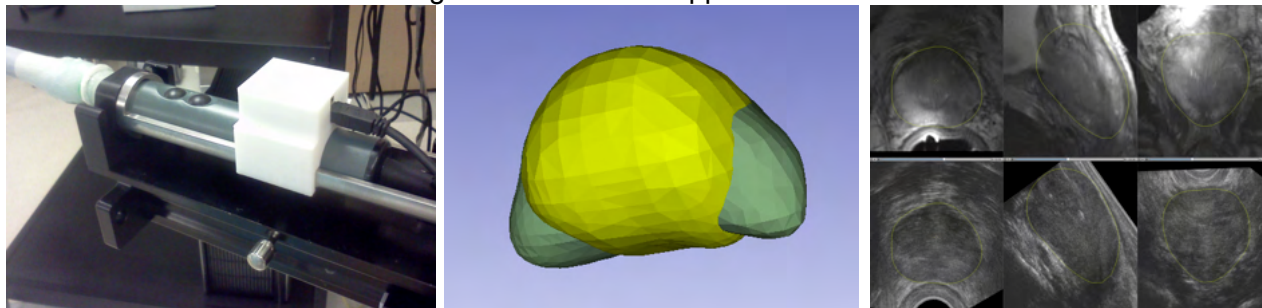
Left: transrectal probe setup with the tracking device attached. Middle: Rendering of the prostate gland surfaces recovered from MRI (green) and reconstructed TRUS (yellow) after rigid alignment. Right: Reformats of the T2w MRI and 3D TRUS after non-rigid registration.
